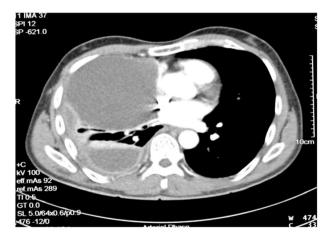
Contrast enhanced computed tomography scan of the thorax shows a well-defined homogenous anterior right mediastinal mass with adjacent lung collapse as well as pleural effusion with passive lung collapse posteriorly. Note that the cystic nature of the mass may be mistaken for a loculated pleural effusion.
